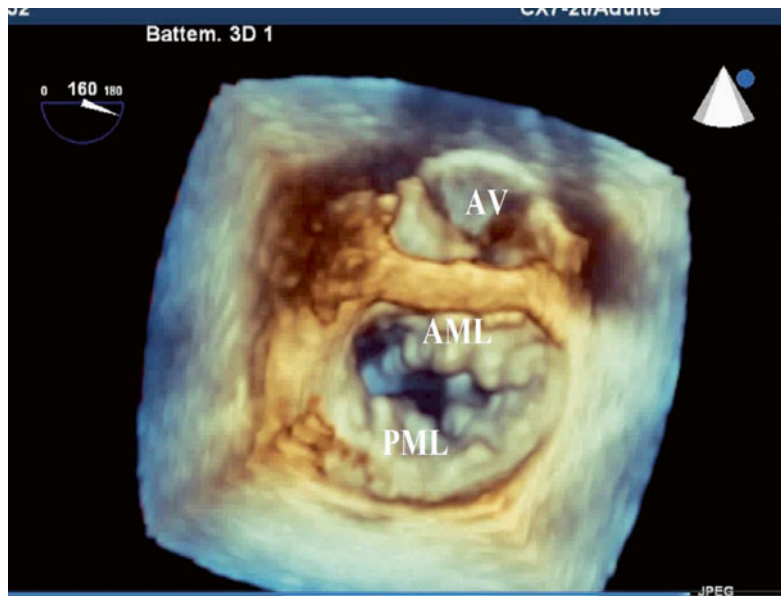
Mitral valve and mitral annulus morphology in three-dimensional transesophageal echocardiography. *AV* aortic valve, *AML* anterior mitral leaflet, *PML* posterior mitral leaflet
